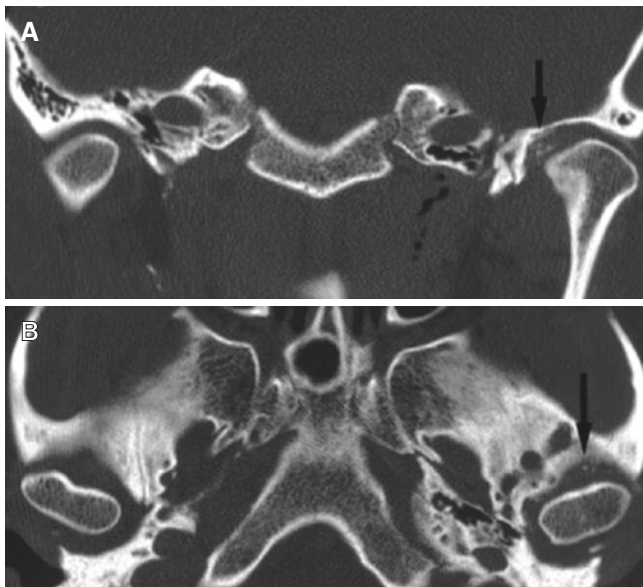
Pseudogout. (A) Coronal and (B) axial CT images show subtle calcifications within joint space (*arrows*) consistent with early stage
